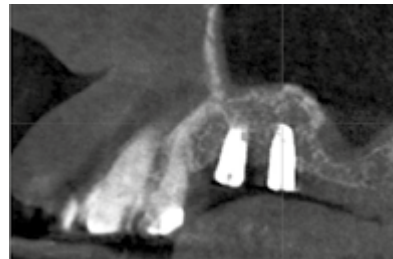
CBCT a 4 mesi dall'osteointegrazione.
